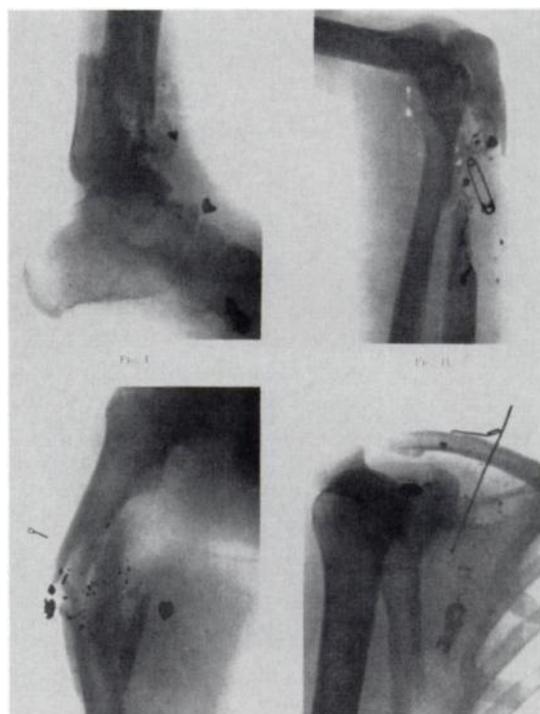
Radiographs of wounded soldiers examined by Dr Stoney in Cherbourg, France, show fractures and associated shrapnel fragments. (Reproduced from reference 27.)
